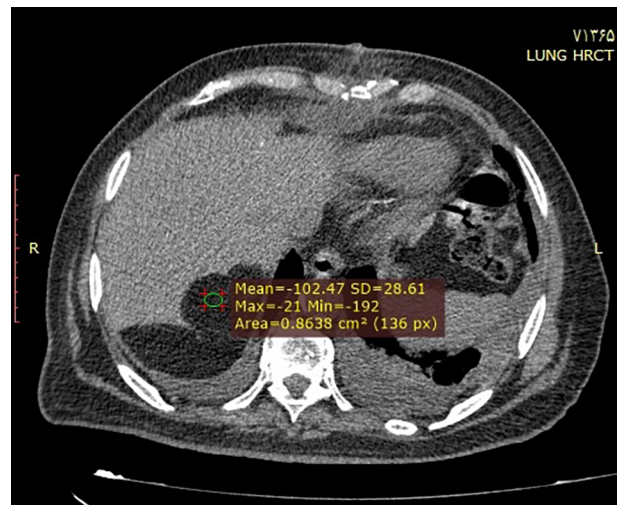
Non-contrast axial CT images show two hypodense, well distinct masses in segment 7 of the liver with an average density of -102.
